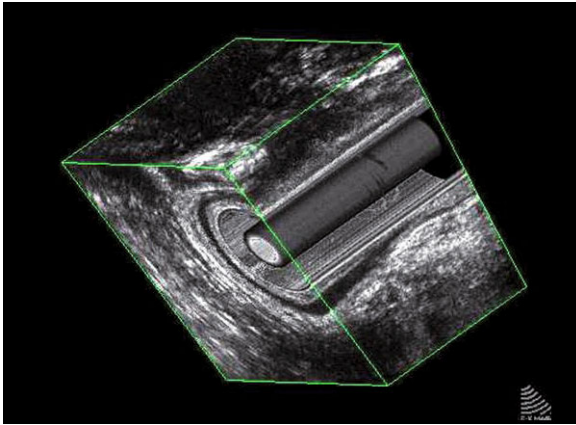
Three-dimensional endovaginal ultrasonography with volume rendering modality. This technique changes the depth information of a 3D data volume, so information inside the cube is reconstructed to some extent
